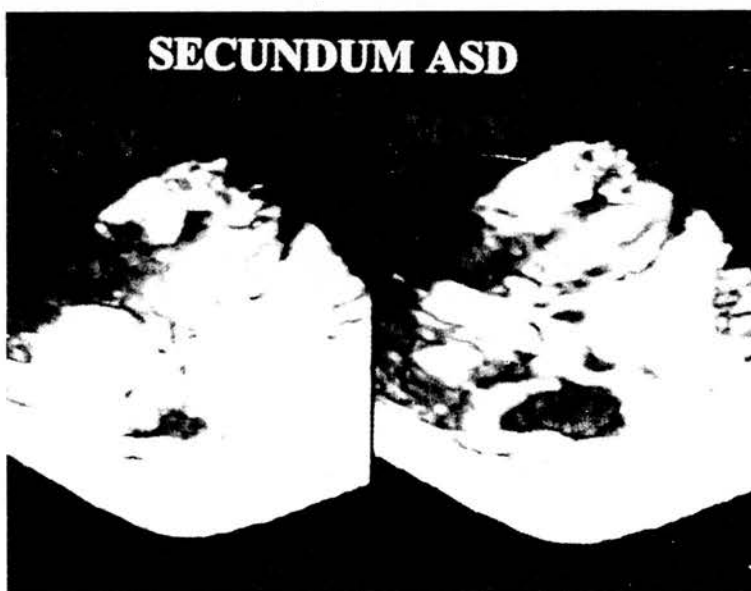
Changes in atrial septal defect (ASD) dimension during a cardiac cycle as seen by three dimensional Doppler myocardial imaging echocardiography.
